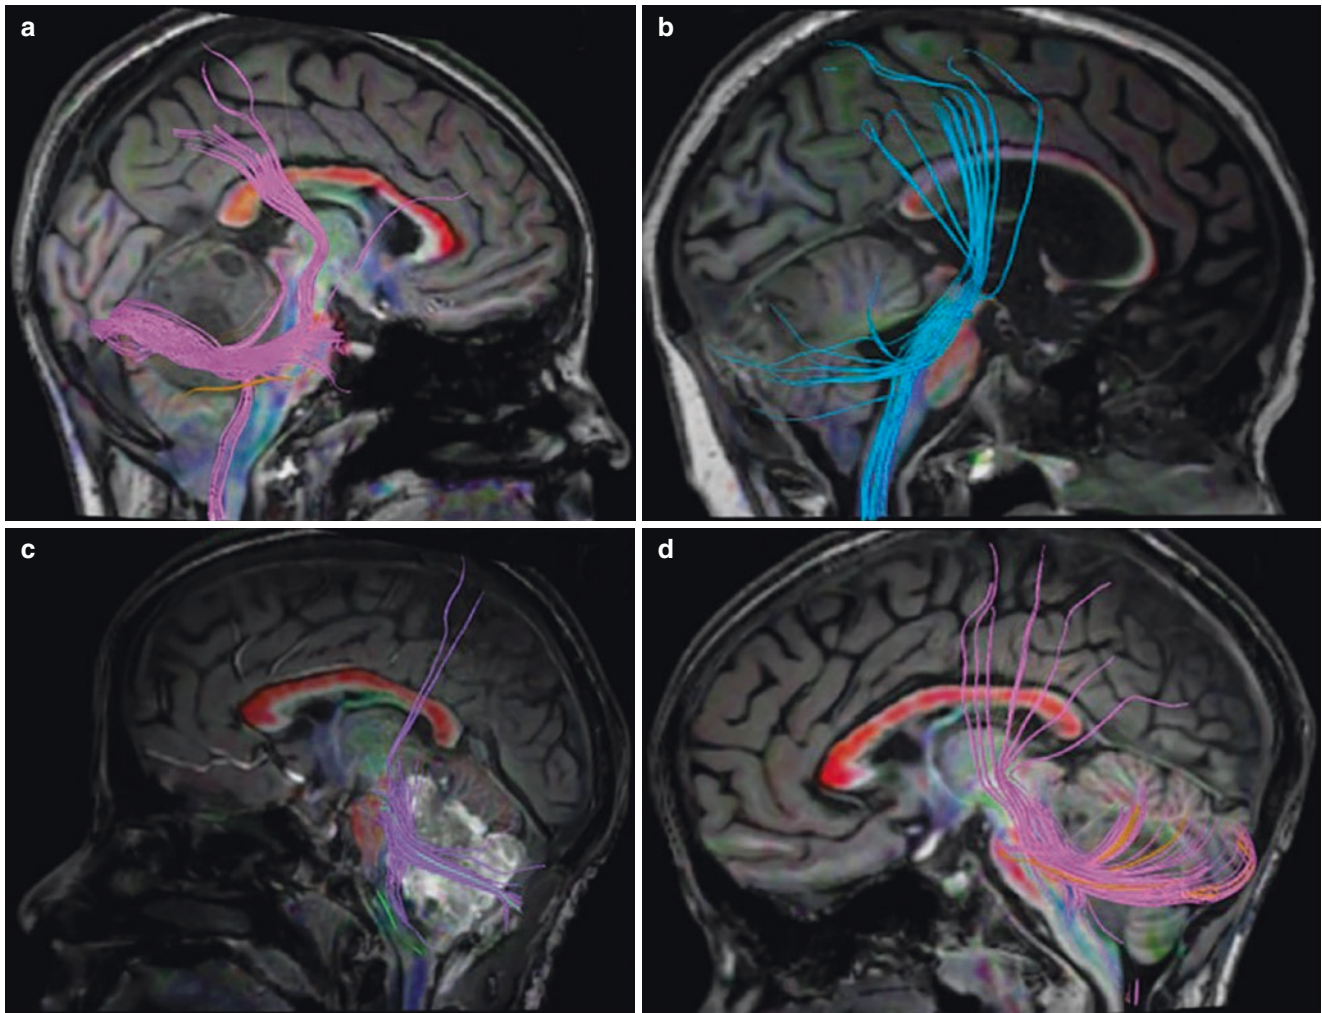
MRI showing diffusion tensor imaging: (a, c) are preoperatively scans, (b) postoperative scan revealing destruction of DTC and patient developed CMS, (d) postoperative scan in which DTC fibers got better with non-occurrence of CMS
